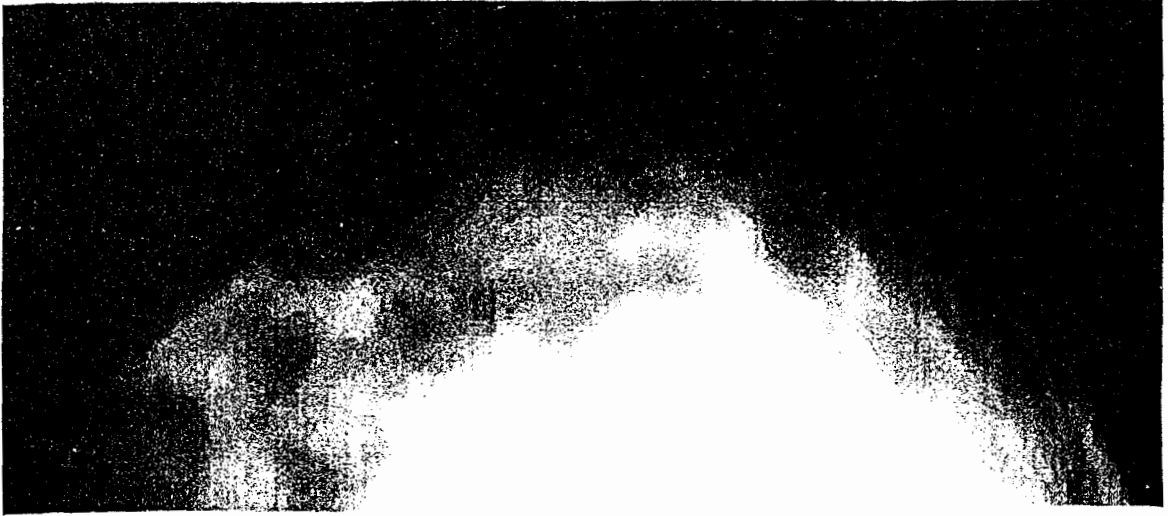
(a) Right breast, x-ray image.
